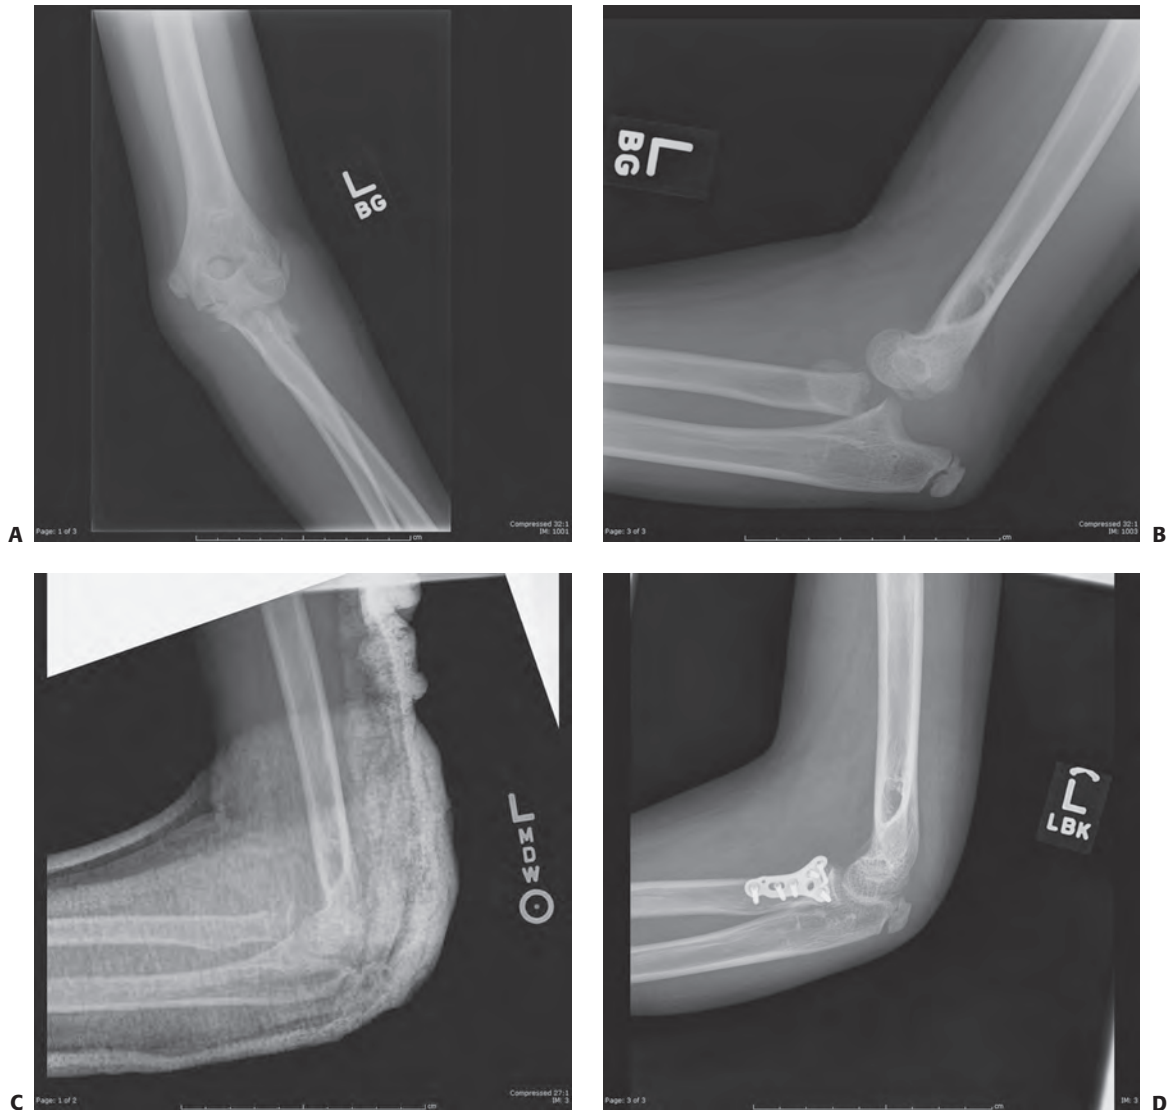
Open reduction internal fixation of a proximal radius fracture (A). AP radiograph of an 11-year-old female with elbow dislocation and radial neck fracture (B). Lateral radiograph of the same patient. C: Lateral radiograph in splint after closed reduction showing persistent radiocapitellar subluxation. Examination under anesthesia demonstrated very unstable elbow joint and therefore decision made to proceed with open reduction internal fixation (D). Lateral radiograph after open reduction internal fixation with a fracture-specific plate.
